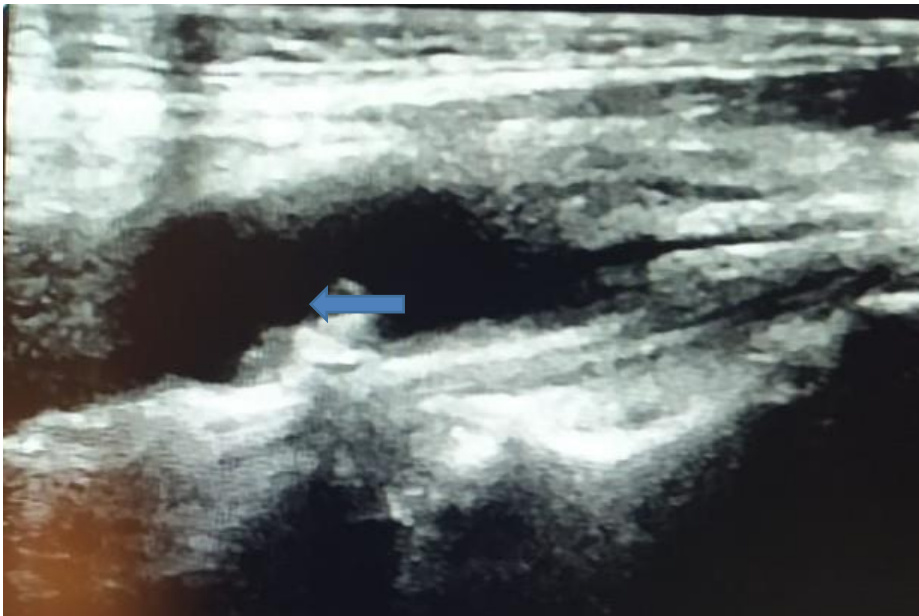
Sonographic image of axial view shows heterogeneous plaques in the common carotid artery of a left carotid artery causing stenosis < 70%. (Highlighted by blue arrows)
